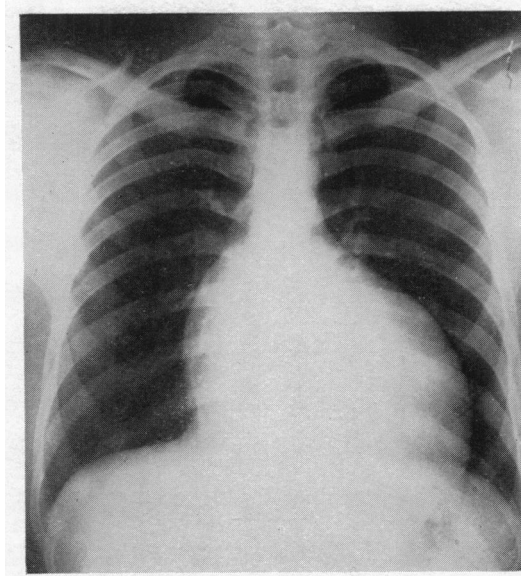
Roentgenogram of the heart in the postero-anterior view. Note the marked decrease in the vascularity of the lung fields.
